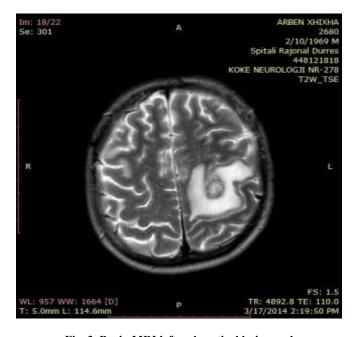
Brain MRI left subcortical lesion and parietal lesion
